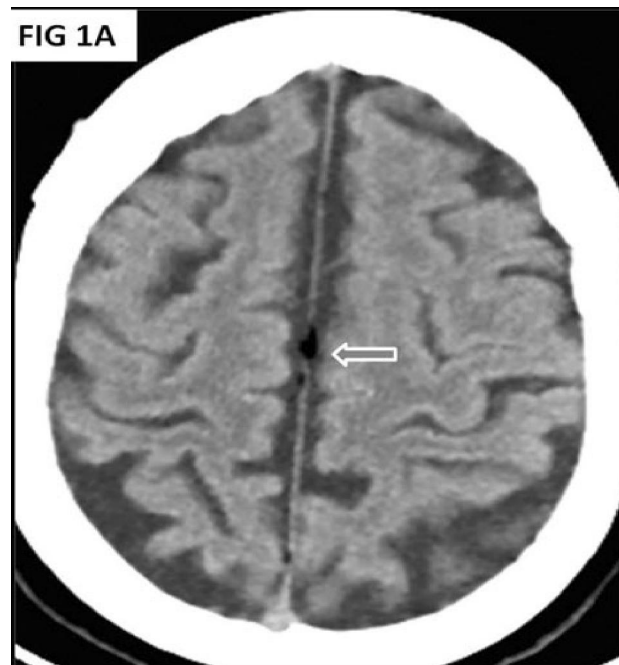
and 1B: NECT brain showing hypo dense fatty falx in midline having a CT density of -20 H.U.
